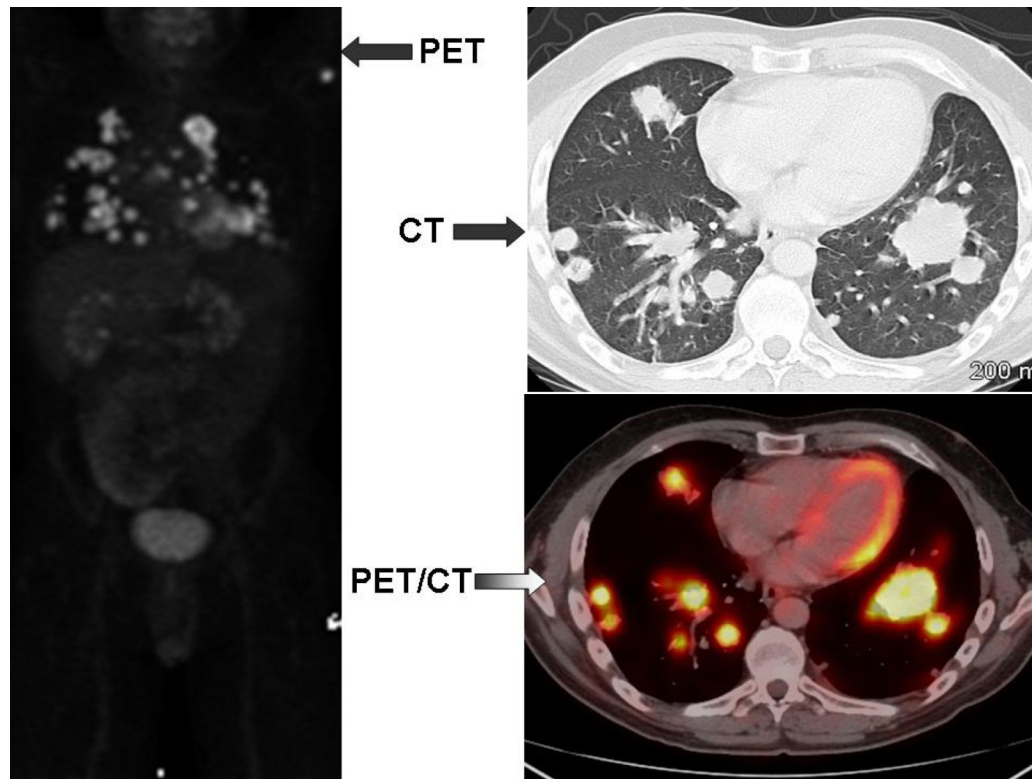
PET, chest CT and fused PET/CT images on a patient with multiple pulmonary metastasis from colon cancer.
